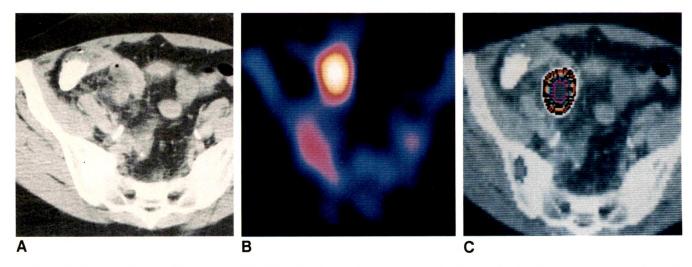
A, CT scan. A 55-year-old woman presented with persistent generalized abdominal pain. CT scan shows nonspecific bowel-wall thickening in right lower quadrant.
